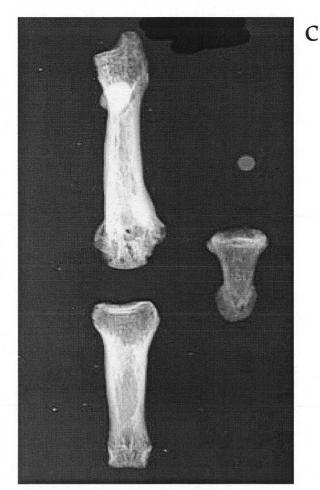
contd. c; A radiograph of the metacarpal from (a) and (b) with associated proximal and distal phalanges.
